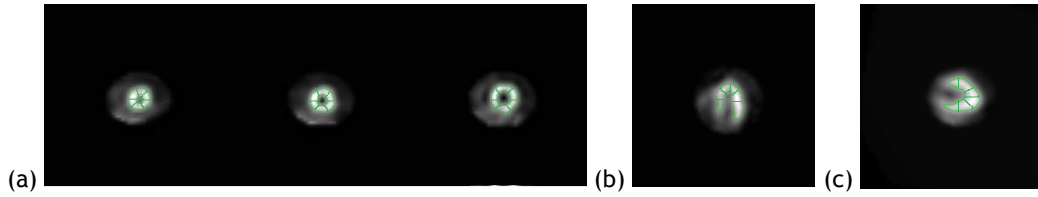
20-segments coronary artery mapping template SPECT for stress studies: (a) SA ; (b) HLA ; (c) VLA.
